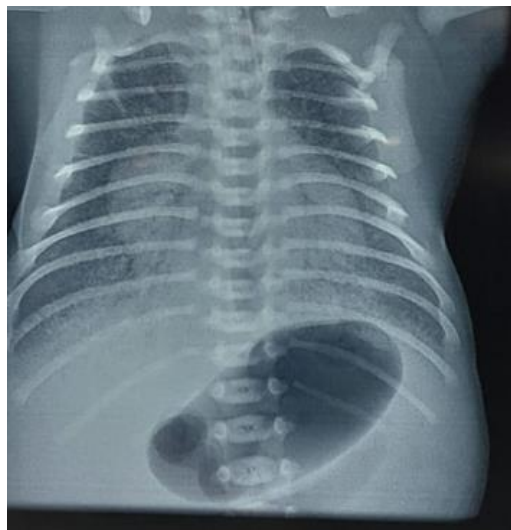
Chest X-ray: Post-Intubation
